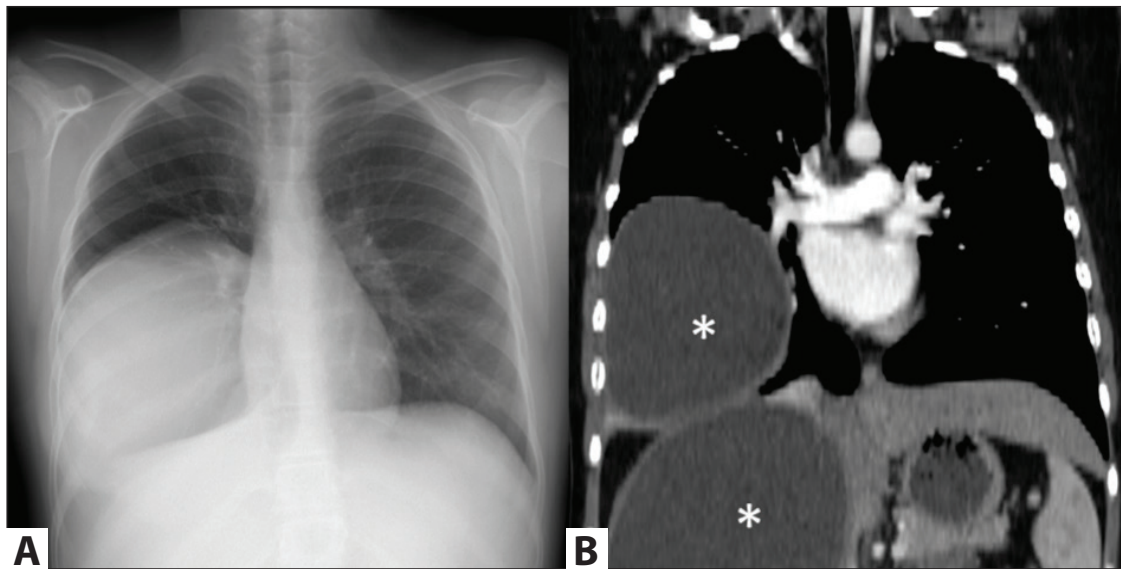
Posteroanterior chest radiography (A) and coronal reformat images (B) of the chest CT.
